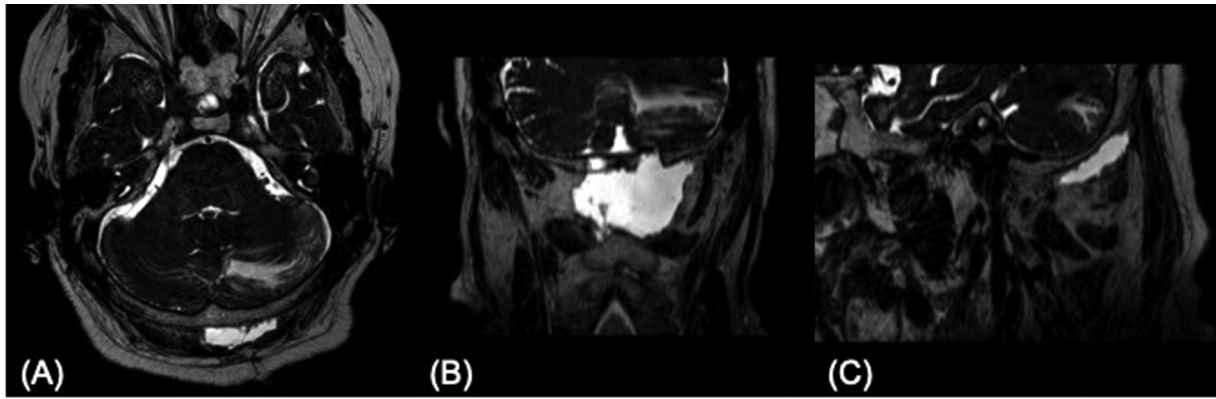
Heavy T2 volume isotropic turbo spin echo acquisition magnetic resonance images of axial (A), coronal (B), and sagittal (C) taken on the 7th day after surgery showed there was cyst formation along the folia.
